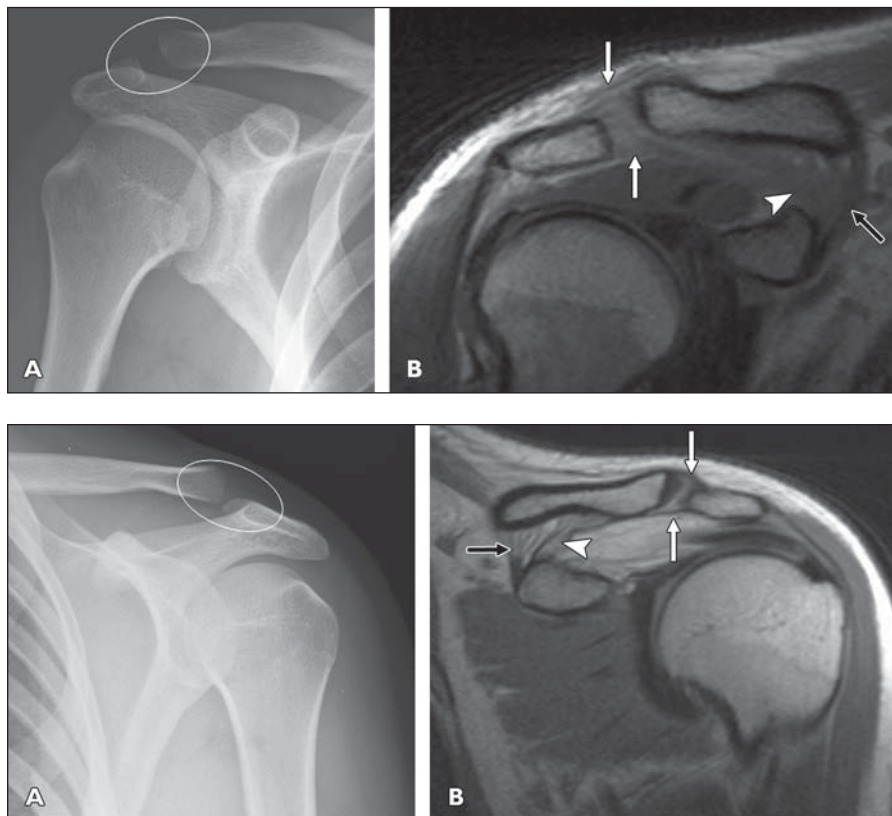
21-year-old man after right-sided acromioclavicular joint trauma with suspected radiographic Rockwood type II injury confirmed at MRI.
